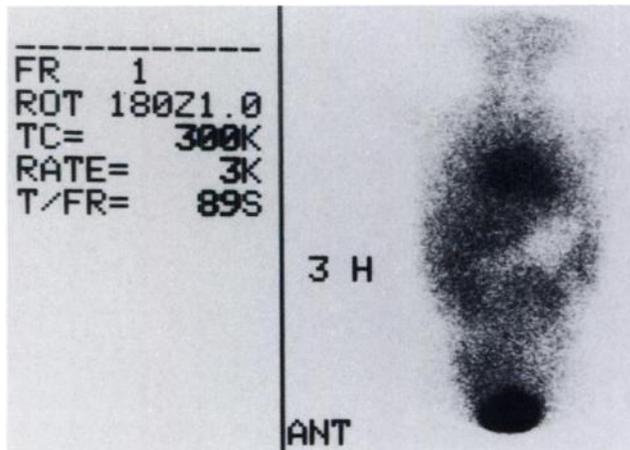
Technetium-99m-HIDA cholescintigram. A very faint hepatic accumulation of radiotracer is noticed after 3 hr. The hepatobiliary system is not visualized.
